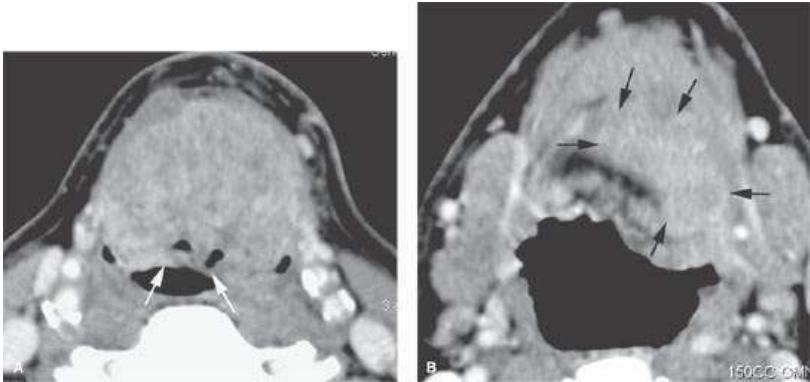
Contrast-enhanced computed tomography in a patient with supraglottic carcinoma. A: Very extensive spread from the pre-epiglottic space into the tongue base. This was all submucosal. The relatively normal suprahyoid epiglottis is still visible (arrows). B: This tumor continued cephalad well into the tongue base, showing a very aggressive infiltrating pattern along the left lingual neurovascular bundle crossing the midline (arrows).
